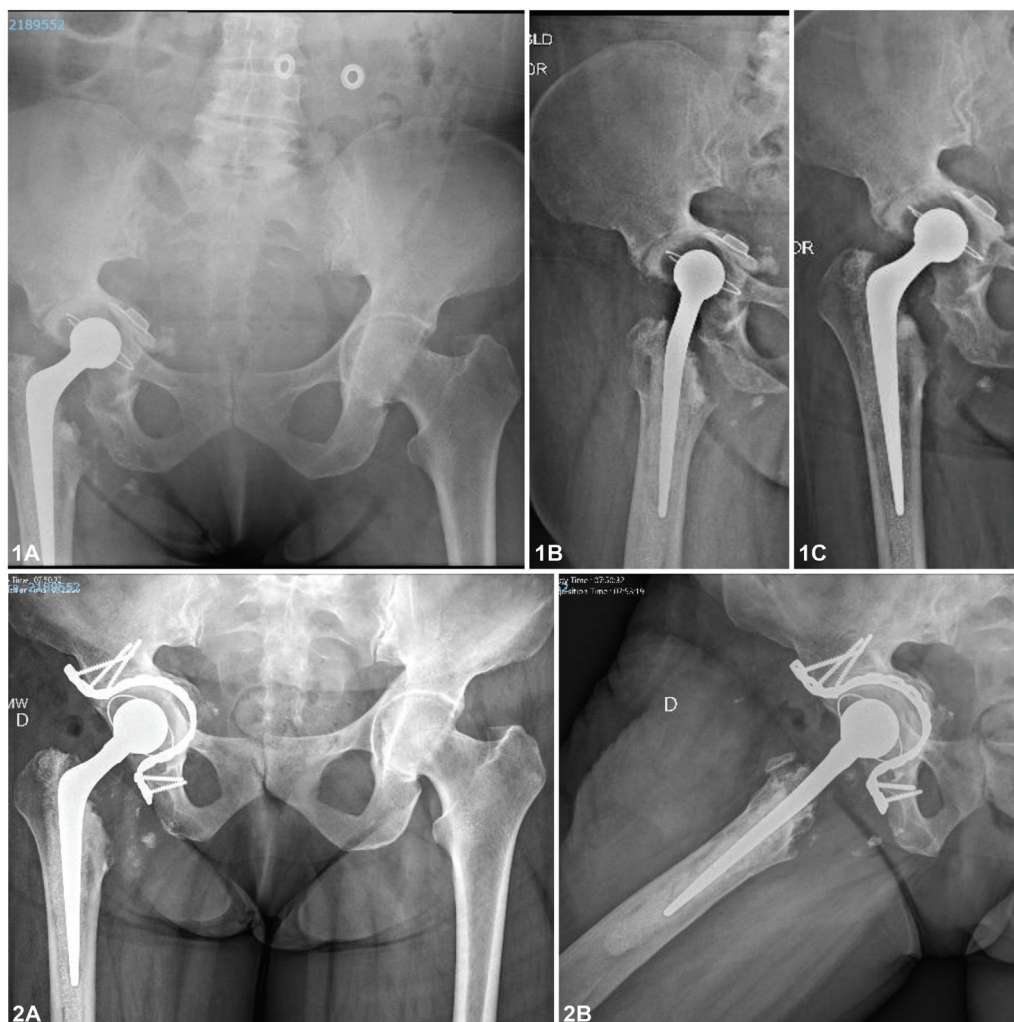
(A) Preoperative radiographs (case 1). (B) Postoperative radiographs.
